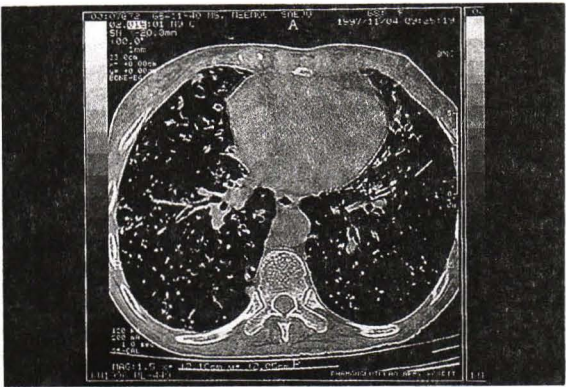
High resolution computed tomographic of case 1; showing diffuse centrilobular nodules and bronchiectatic changes in both lungs.
